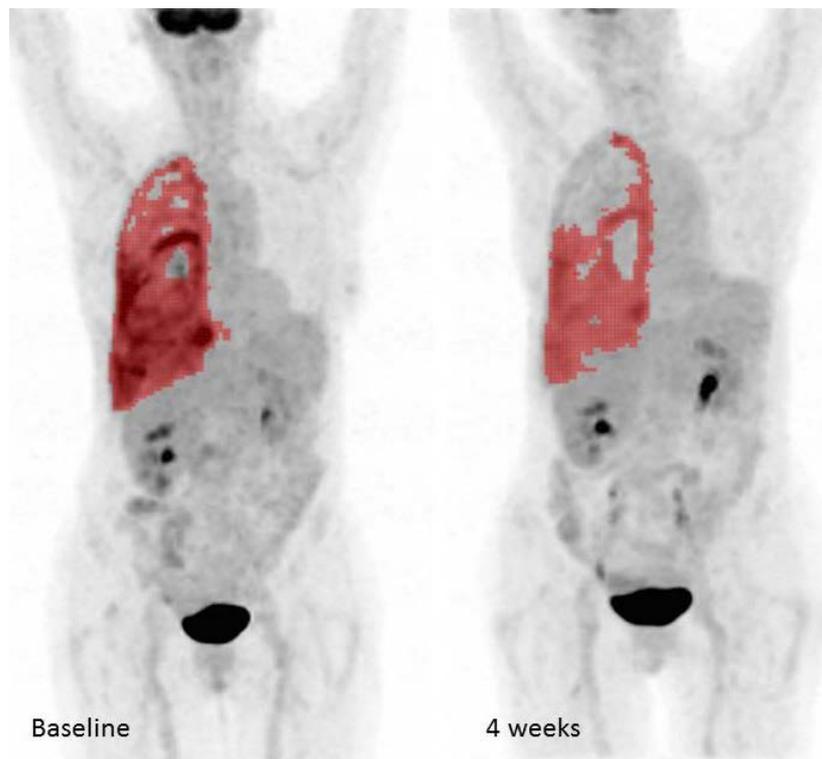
Baseline and 4 weeks post-treatment ^{18}F FDG-PET maximum projection images in a 54 years old woman with sarcomatoid mesothelioma showing good response to therapy.
